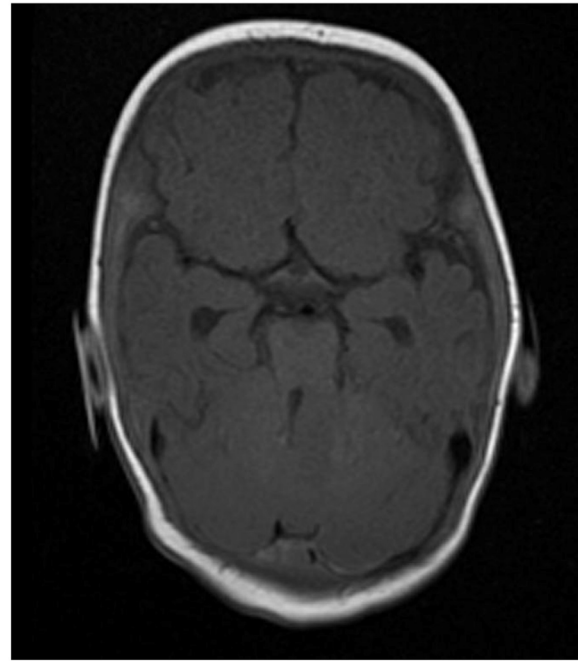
Preoperative axial T1 MRI of the left-centered HFFV involving the cerebellum.
